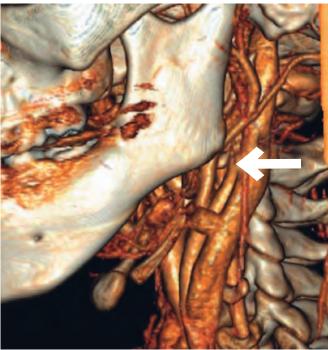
Patient 2. CT reconstruction angiogram with left internal carotid artery occlusion (arrow).
